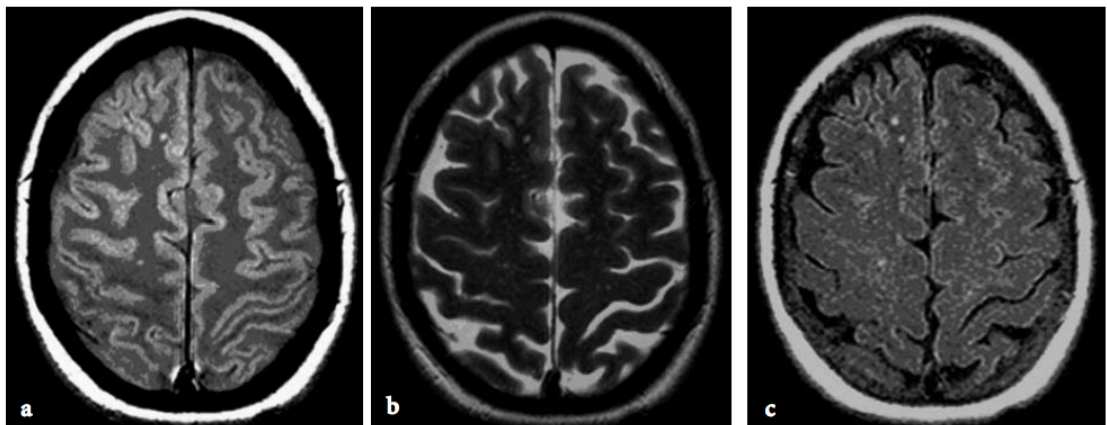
Conventional MRI scans used in the radiological assessment of MS. a) Proton density, b) T₂-weighted, and c) FLAIR scans showing small hyperintense white matter lesions. Source: (Traboulsee et al., 2005).
